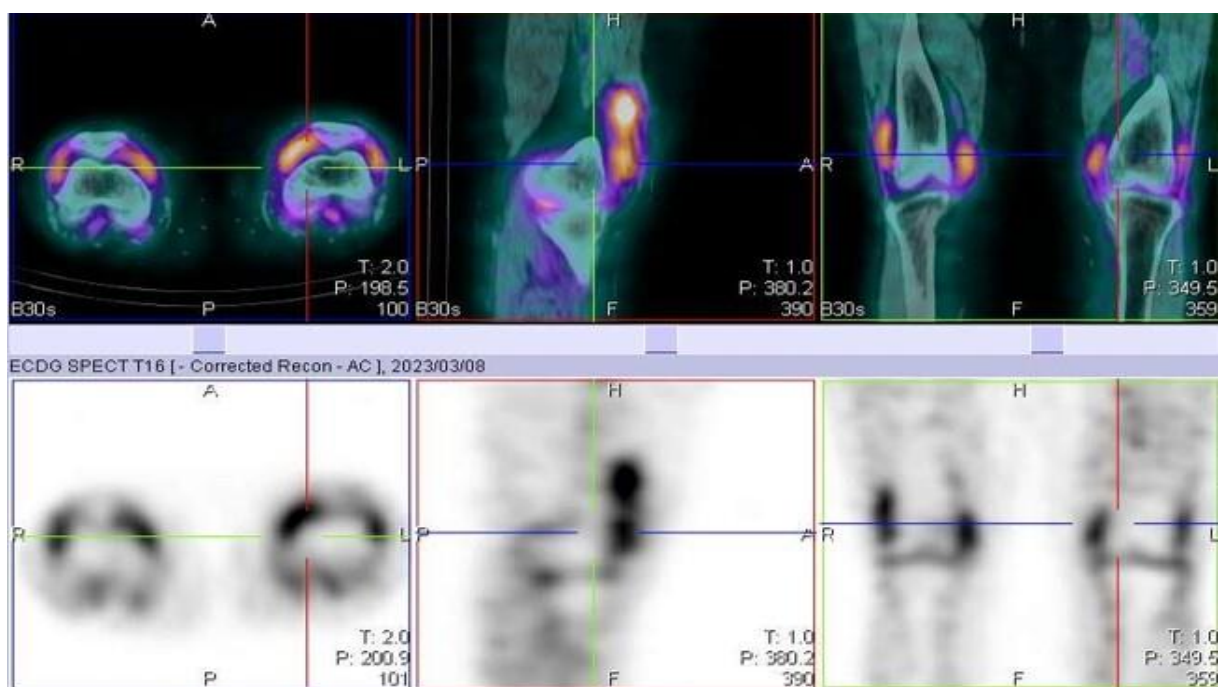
SPECT/CT images of the same patient in Figure 3.2, showing localisation of the intense uptake of ^{99m}Tc -labelled glucosamine in the knee to the synovial space, without bone uptake.
